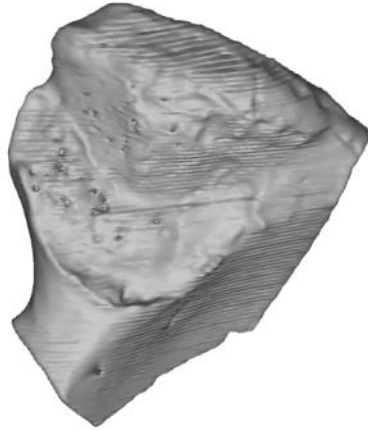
3D segmentation of an auricular surface generated from CT scan with horizontal lines artefacts. CT scans were performed using a Siemens Somatom Sensation 4, 120kV, 200mAs, 1mm slice thickness and 0.3 mm slice increment.
